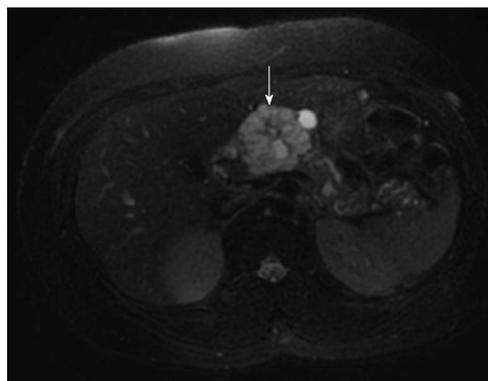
Magnetic resonance imaging of microcystic serous cystadenoma (arrow) in body of pancreas.
